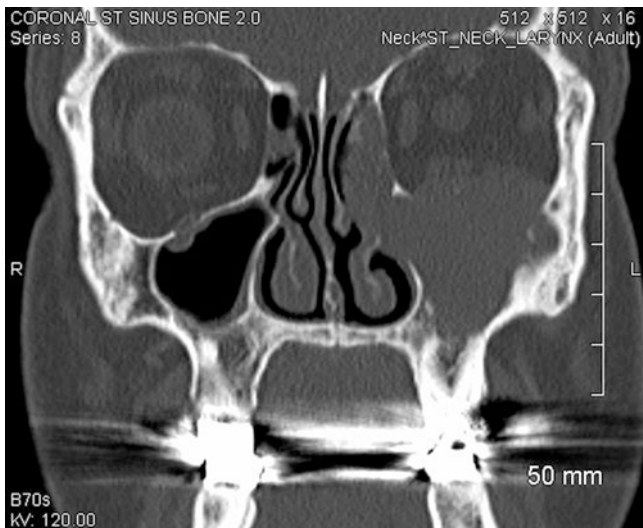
Coronal computed tomography (CT) of the sinuses demonstrating a left-sided nasal cavity mass with opacification of the left maxillary sinus and ethmoid sinuses and invasion into the ipsilateral orbit. Any unilateral opacification of the sinuses is concerning for malignancy
